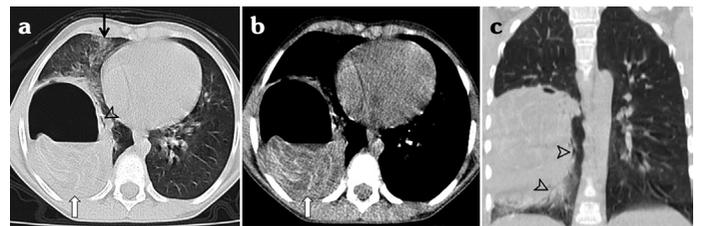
Water lily sign. (a, b) Axial and (c) coronal multiplanar reconstruction computed tomography images of a 25-year-old male patient with a hydatid cyst rupture show crumpled endocyst as floating membrane in the cyst fluid (white arrows). Lung consolidation (black arrow) and airway compression (arrowheads) can also be seen
